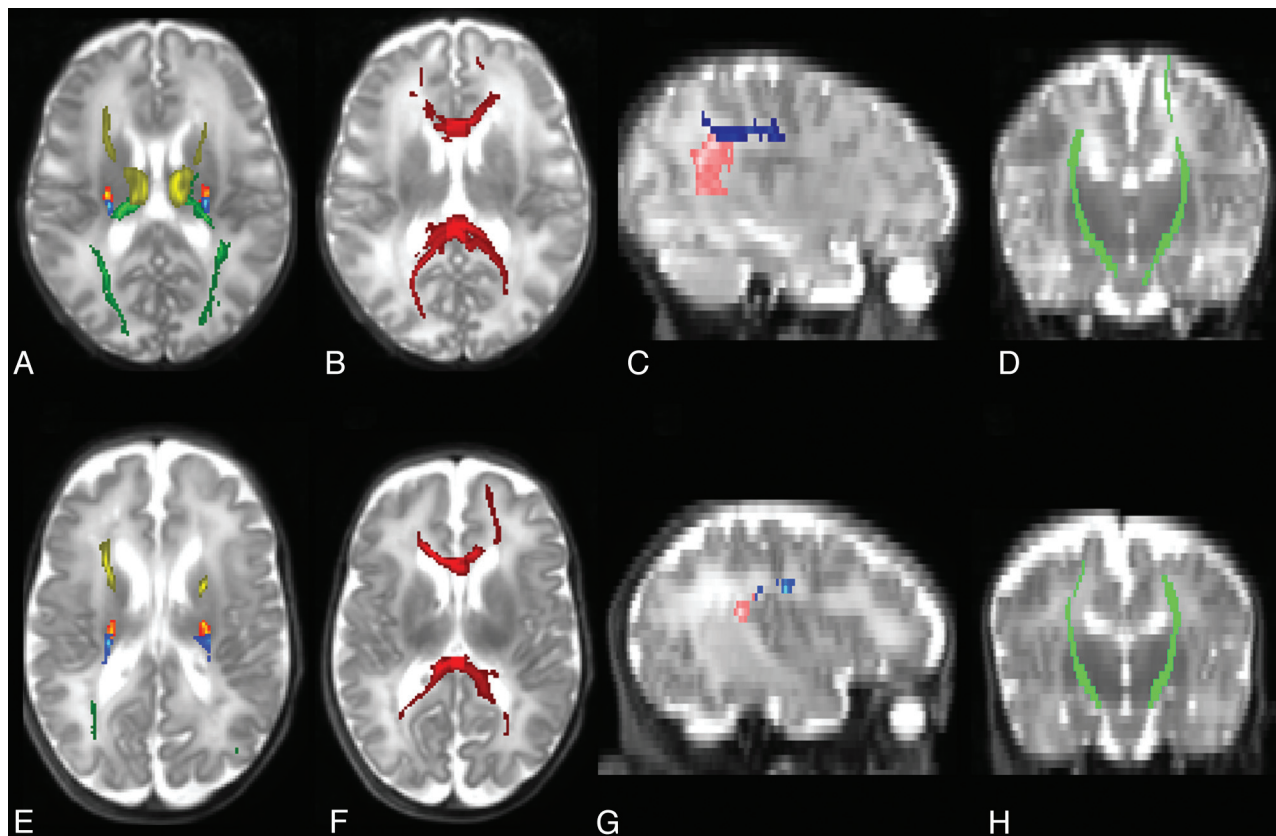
Tracts are shown on T2-weighted images in neonate with no WMA, scanned at 36 weeks corrected gestational age (A–D) and in neonate with moderate WMA, scanned at 38 weeks (E–H). Axial images (A, E) show the TRs (ATR in yellow, motor STR in yellow-red, sensory STR in blue and PTR in dark green). Axial images (B, F) show the corpus callosum (dark red). Sagittal images (C, G) show the frontoparietal SLF (dark blue) and parietotemporal SLF (pink). Coronal (D, H) images show the CSTs (light green). Images were obtained from a 1.5T magnet (Philips Achieva, Best, The Netherlands).
